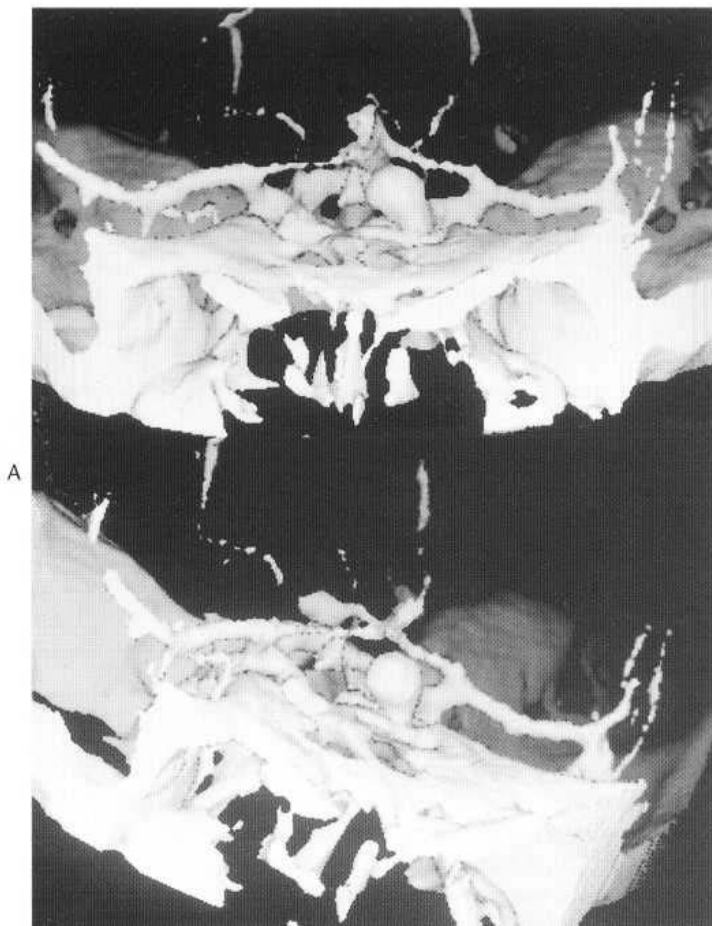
3D CT reconstruction of circle of Willis and adjacent vessels showing bilateral aneurysms. (A) AP view. (B) Computer-rotated view. (Courtesy of Dr A. Al-Kutoubi.)
